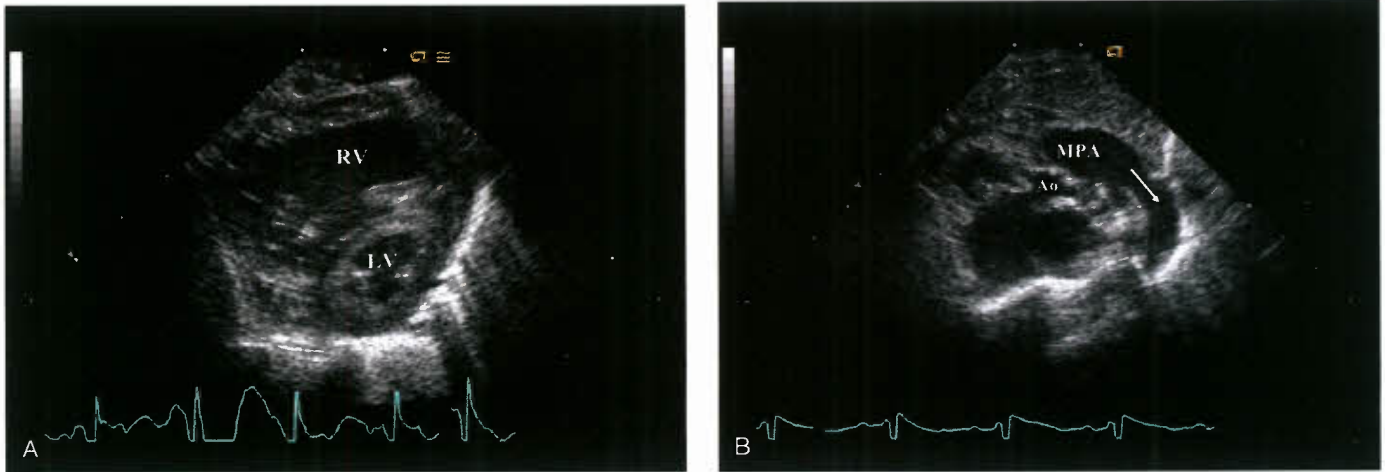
Parasternal short-axis views in a patient with HLHS. In (A) the right ventricle (RV) is enlarged with a smaller hypertrophied left ventricle (LV). Scanning more superiorly from a parasternal short-axis view (B), the larger main pulmonary artery (MPA) and patent ductus arteriosus (*arrow*) are seen connecting to the descending aorta. No brachiocephalic vessels are seen arising from the ductal arch, a key finding in differentiating the ductal arch from the true aortic arch. Ao aorta.
